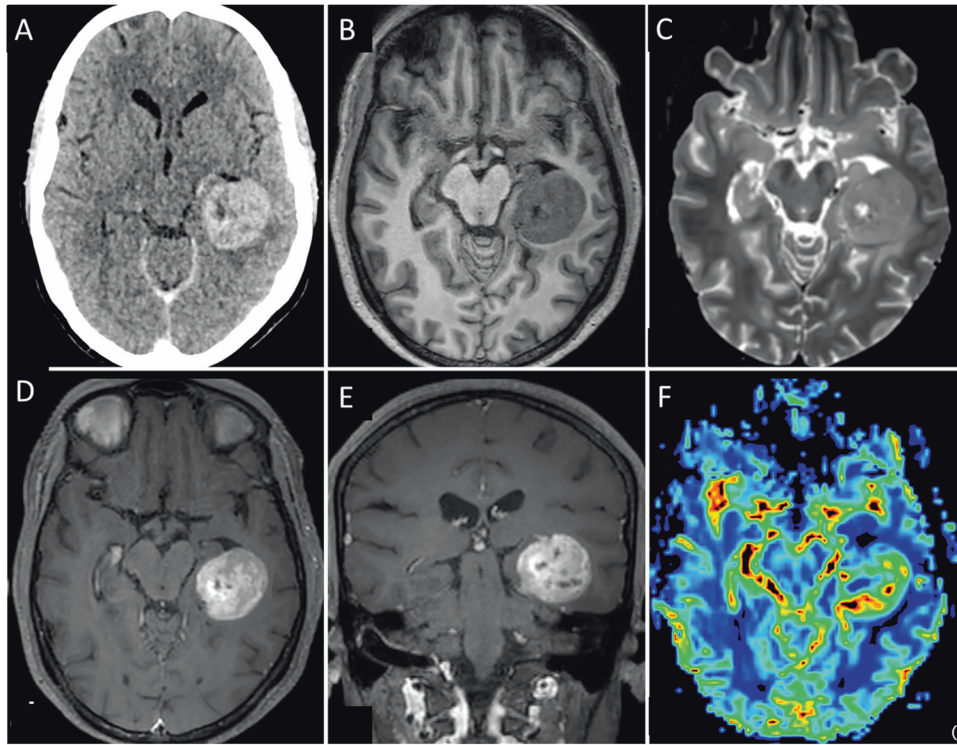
Imaging characteristics of a case of epitheloid glioblastoma. CECT image (A) shows an intensely enhancing mass lesion with few cystic components in left temporal lobe. On MRI, lesion is isointense on T1- (B) and T2-WI (C) with minimal perilesional edema. On postcontrast axial (D) and coronal (E) T1-WIs, lesion appears to be cortical based and shows vivid enhancement with few nonenhancing cystic components. Dynamic susceptibility perfusion imaging (F) shows significant raised perfusion in the lesion suggesting highly malignant lesion.
